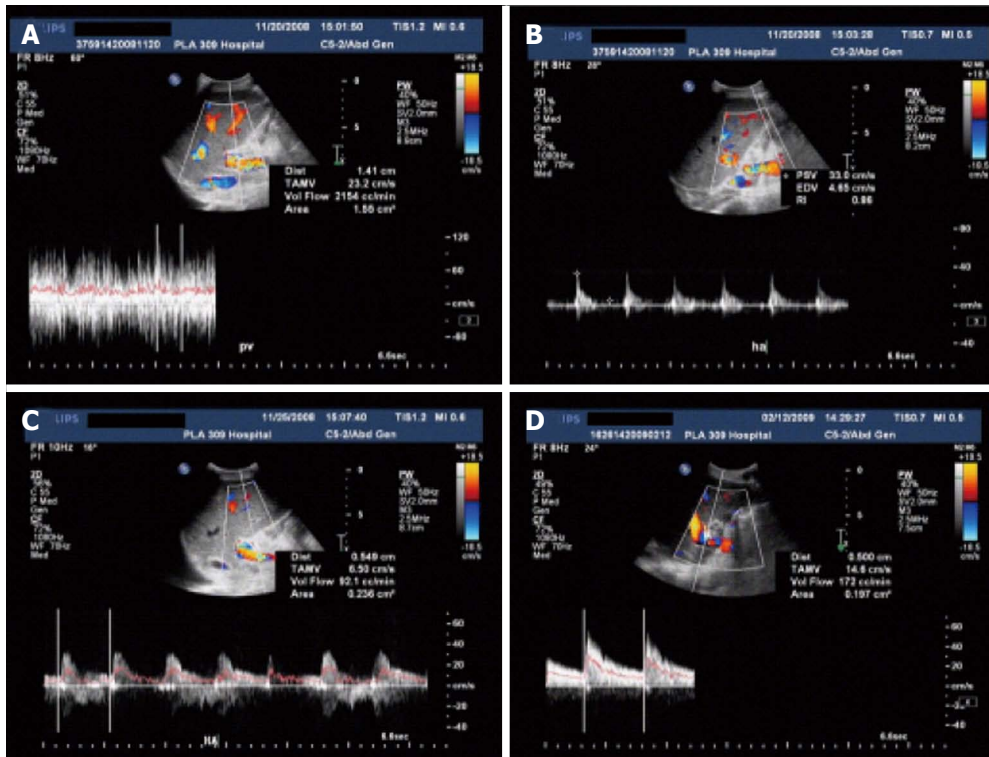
Doppler images during occluding the splenic artery. A: Normal portal vein and disappeared hepatic artery flow signal as revealed by Doppler ultrasonography on the 2nd day after transplantation; B: Reappearance of the hepatic artery flow signal revealed by Doppler ultrasonography after the treatment by occluding the splenic artery temporarily; C: Better hepatic artery flow signal on the 5th day after the treatment; D: Normal hepatic artery flow signal at the end of the 3th month after the orthotopic liver transplantation.
